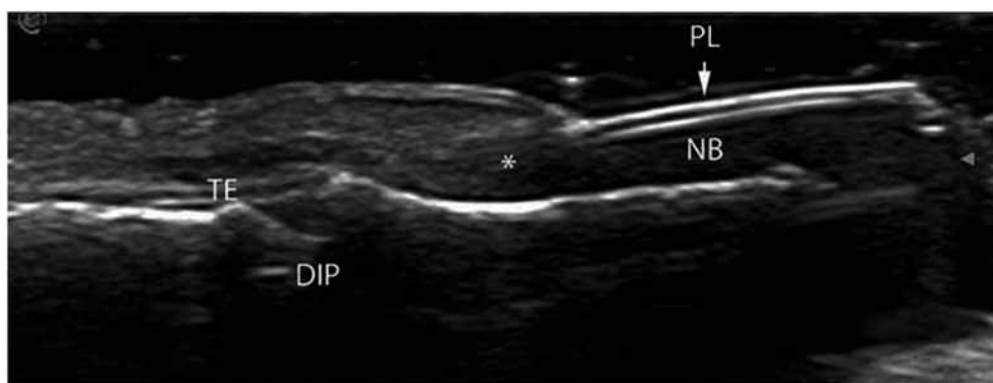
Sonography of normal nail . © X. Wortsman, Chile
